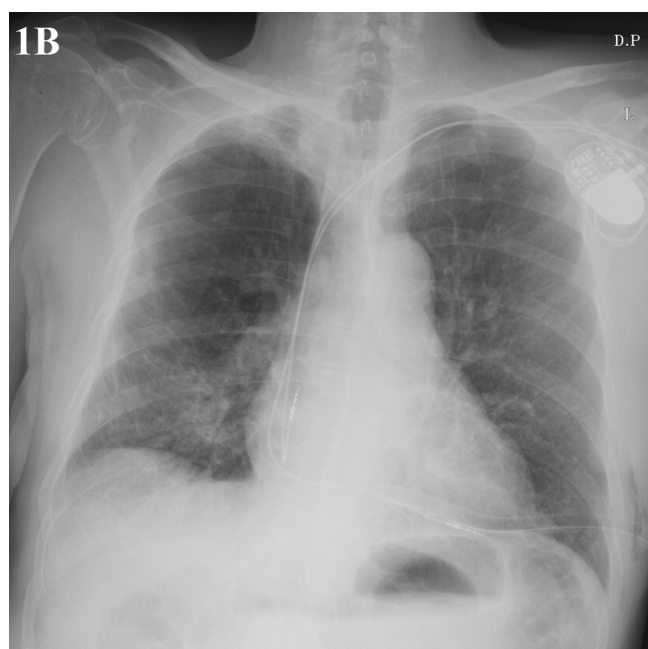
Chest X-ray — state directly after pneumothorax evacuation; in pleural space visible chest tube.
